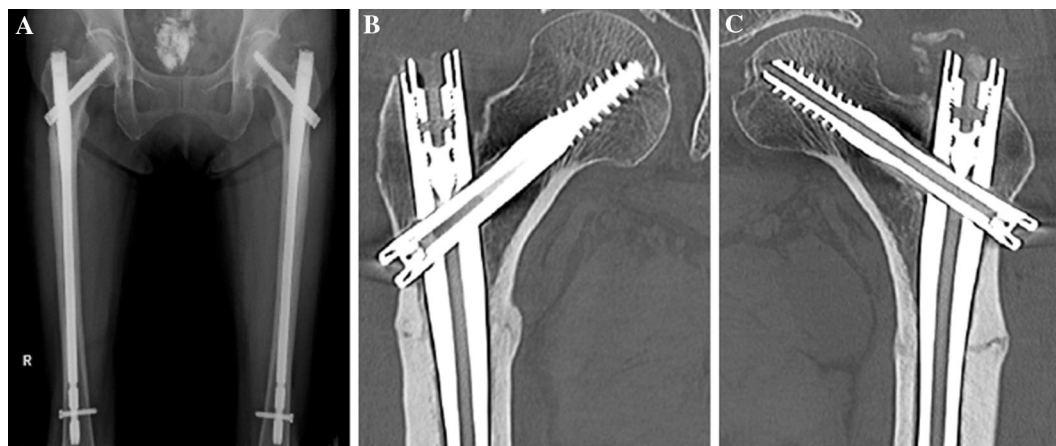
Radiograph and CT imaging after 3 months of TPTD therapy. a Radiograph imaging after 3 months of TPTD therapy shows complete union of fractures. b CT imaging after 3 months of TPTD therapy shows complete
